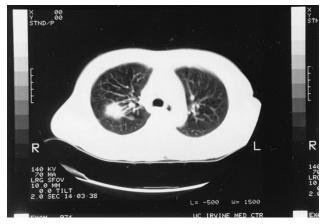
Computed tomography scan of the chest showing a dense mass in the right upper lobe and thickened bronchial walls giving the appearance of a tennis racket.
